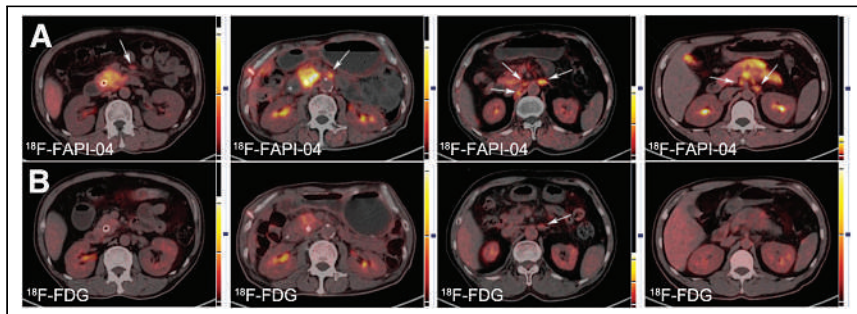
Typical LN PET/CT images obtained with ^{18}F -FAPI-04 (A) and ^{18}F -FDG (B) from 4 patients. Lesion is marked by arrows.
